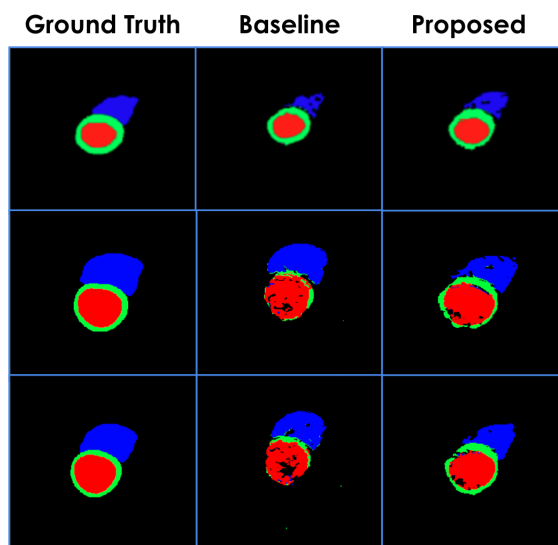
Qualitative Results for the semi-supervised cardiac MRI segmentation using image registration: (Red) Left Ventricle, (Green) Myocardium, and (Blue) Right Ventricle.
